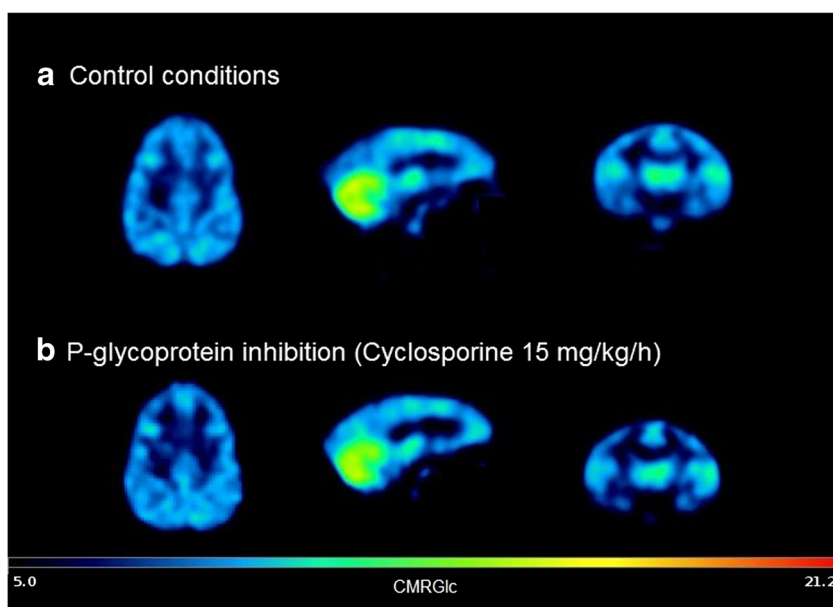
Representative CMR_{Glc} parametric maps obtained in the brain of control (a) and cyclosporine-treated (b) baboons anesthetized using isoflurane. CMR_{Glc} reflects the local glucose metabolism ($\mu\text{mol}/\text{min}/100\text{ g}$). Parametric map was generated using PMOD® software (version 3.5) starting from ^{18}F -FDG dynamic PET images, arterial input function, plasma glucose, and a lumped constant set at 0.89
